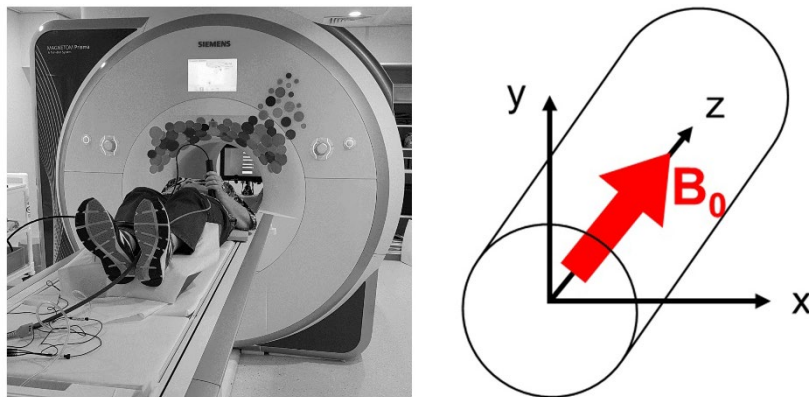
MRI environment. Picture of an MRI scanner (left) with its modelisation with orientation axes and orientation of B_0 , the main magnetic field (right).
